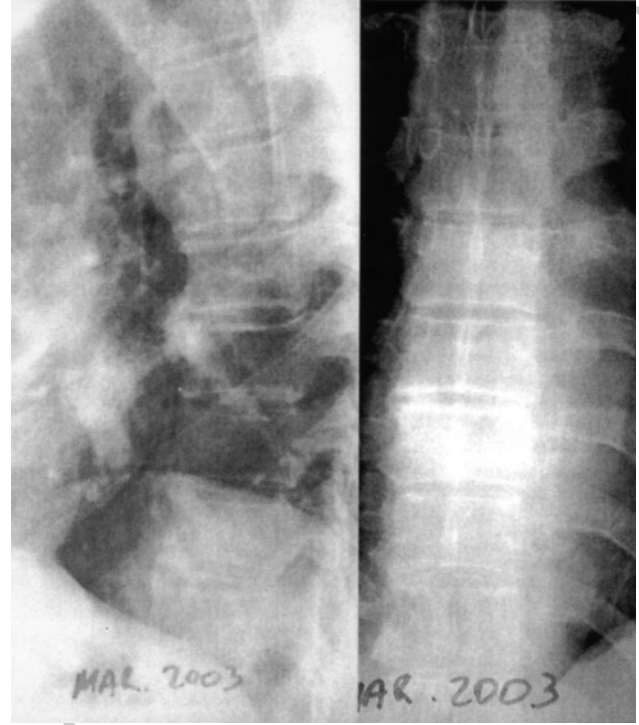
Radiograph in 2003 shows small single bridging osteophyte of the thoracic spine.
